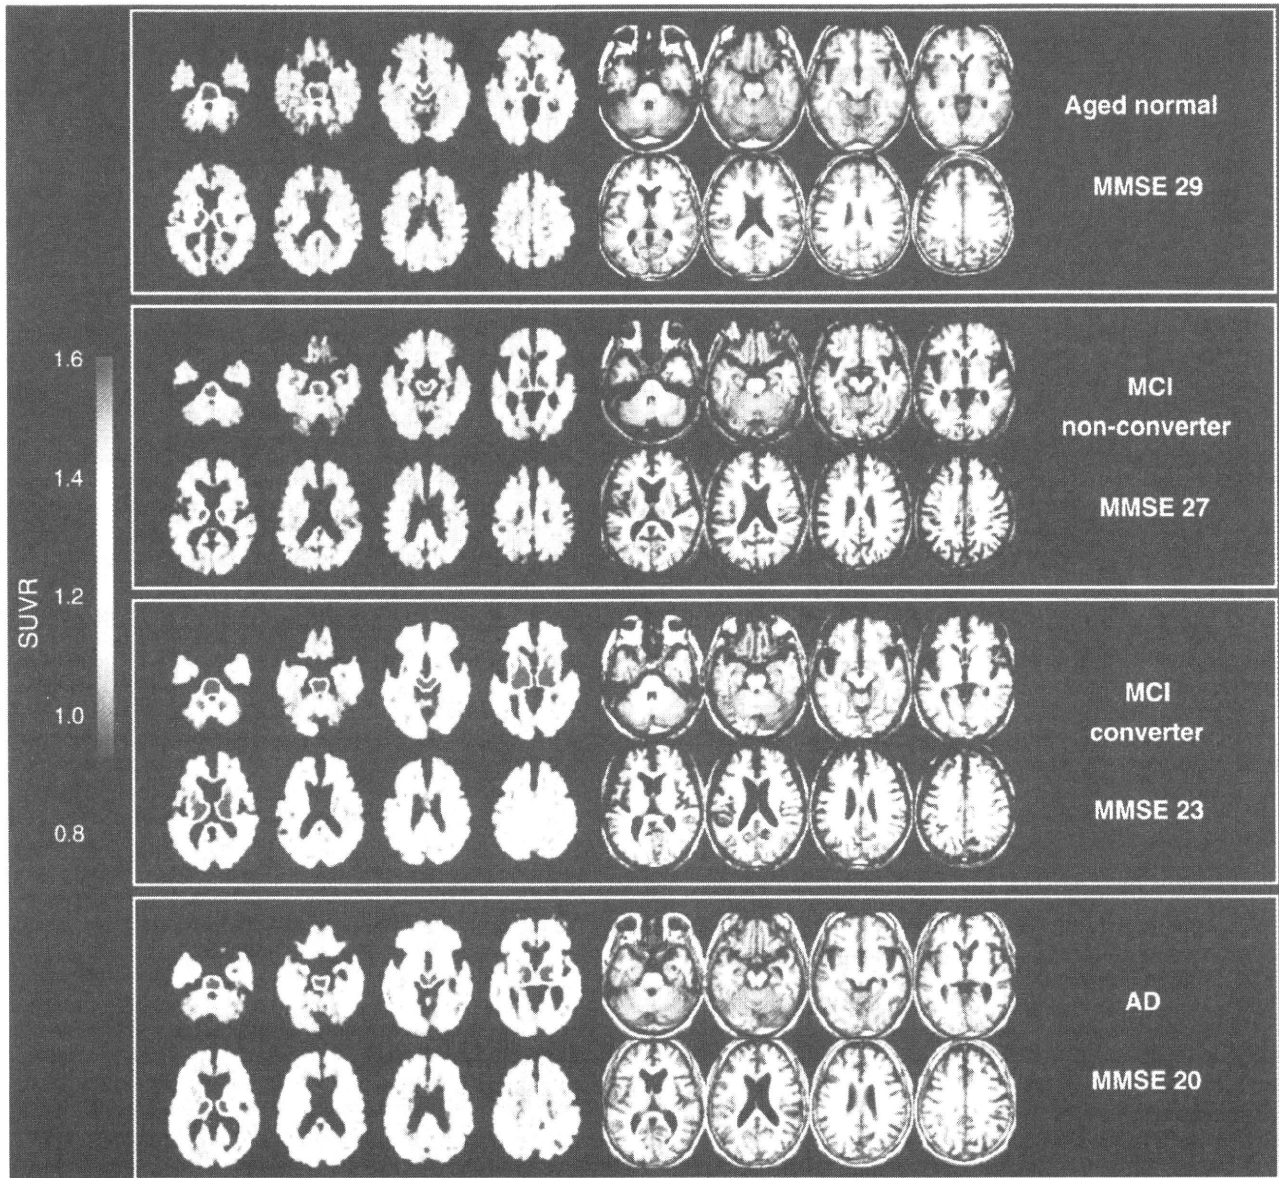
Representative images of [^{11}C]BF-227-PET SUVR between 20 and 40 min post-injection (left) and T1-weighted MRI (right) in a control subject, a MCI non-converter, a MCI converter and an AD subject. The degree of [^{11}C]BF-227 retention is shown by color intensity from yellow to red in the cortex.
